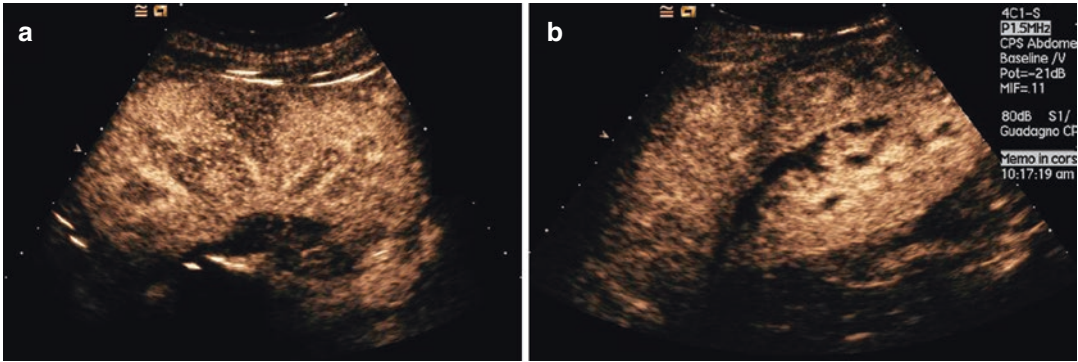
Effectiveness of CEUS as diagnostic tool. (a) In acute pyelonephritis microbubbles identify hypoenhanced areas due to inflammation, edema, and pus collection with performances comparable to CT. (b) Renal
